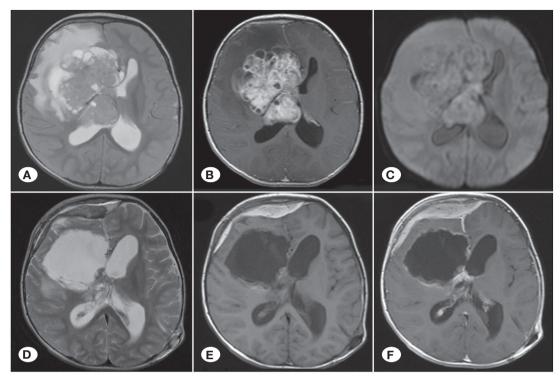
Preoperative and postoperative MRI scans of patient number 21 in Table 1. T2 weighted axial MR image shows a frontal intraparenchymal tumor. Tumor infiltrates right lateral ventricle and posterior part of third ventricle. There is significant peritumoral white matter edema in right frontal lobe which is demonstrated with hyper-intense signal changes (A). Tumor enhances heterogeneously after intravenous contrast agent administration. The solid central part is accompanied by numerous cystic structures on the periphery (B). Tumor shows high signal intensity on diffusion-weighted images, due to tumor's high nucleus-cytoplasm ratio and hypercellularity (C). Postoperative T2 weighted (D), pre-contrast T1 weighted (E) and T1 weighted contrast enhanced (F) axial MR images show gross total tumor excision. Ventriculoperitoneal shunt reservoir and part of ventricular catheter may also be seen on the left side in these images (D, E, F).
